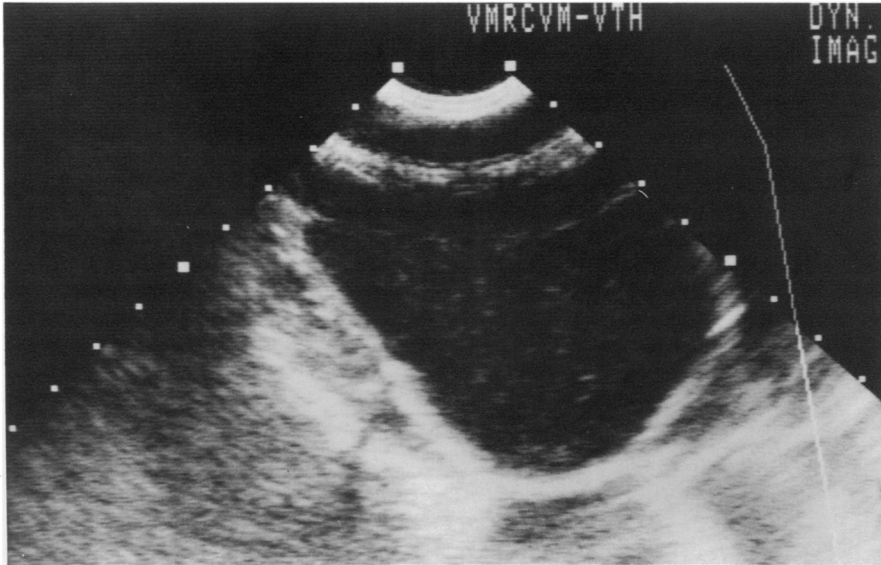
Abdominal sonogram showing enlarged hypoechoic mass with no distal acoustic enhancement. A smaller hyperechoic mass is visible dorsal to this mass.
